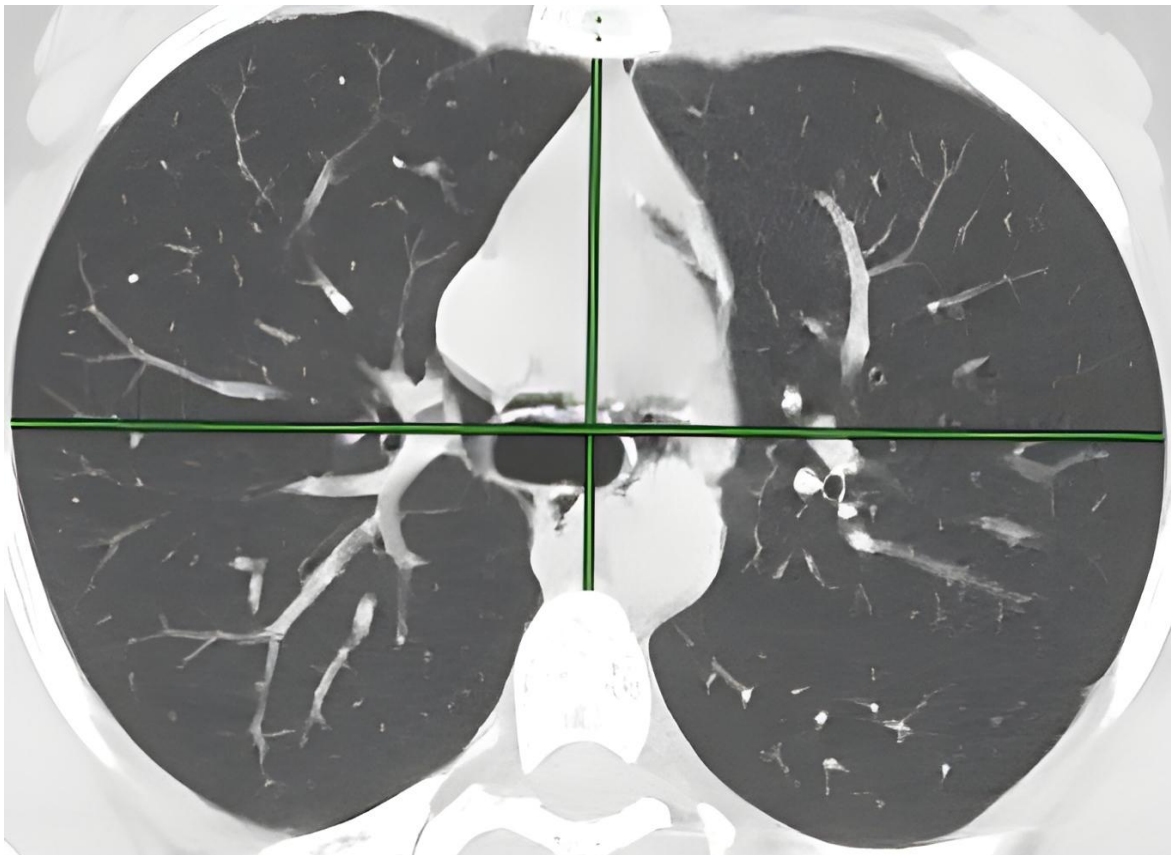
Thoracic anteroposterior and transverse distances measured at the carinal level on an axial CT image
